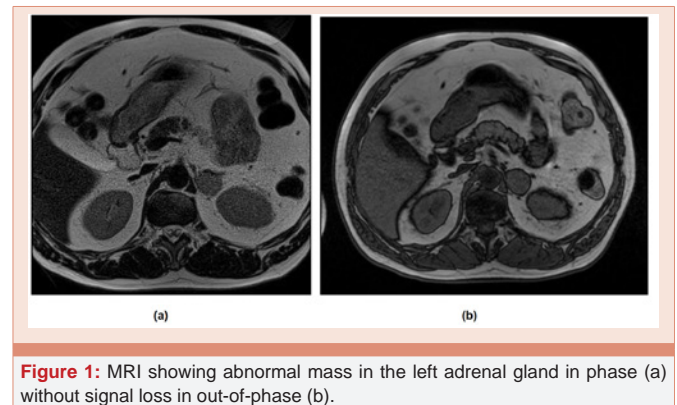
MRI showing abnormal mass in the left adrenal gland in phase (a) without signal loss in out-of-phase (b).
